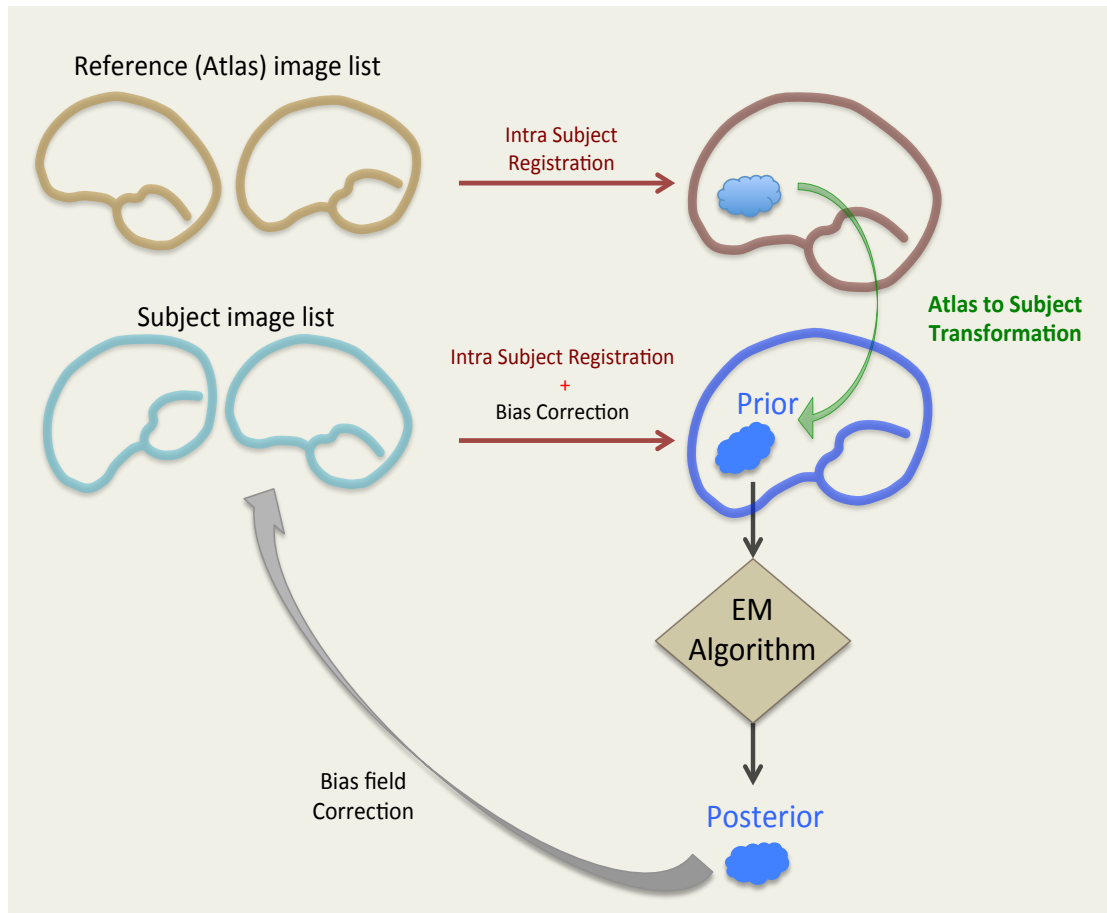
A rough demonstration of iterative classification process by (Kim and Johnson, 2013) using expectation maximization (EM) method. In our development, the EM output posterior probability maps and the input multi-modal MR images are used to train a fuzzy k-NN classifier.
